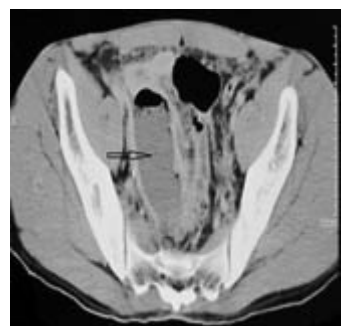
Computed tomographic scan showing a hypodense well defined collection with air fluid level associated with inflammation of surrounding fat in favor of appendiceal abscess (arrow).
